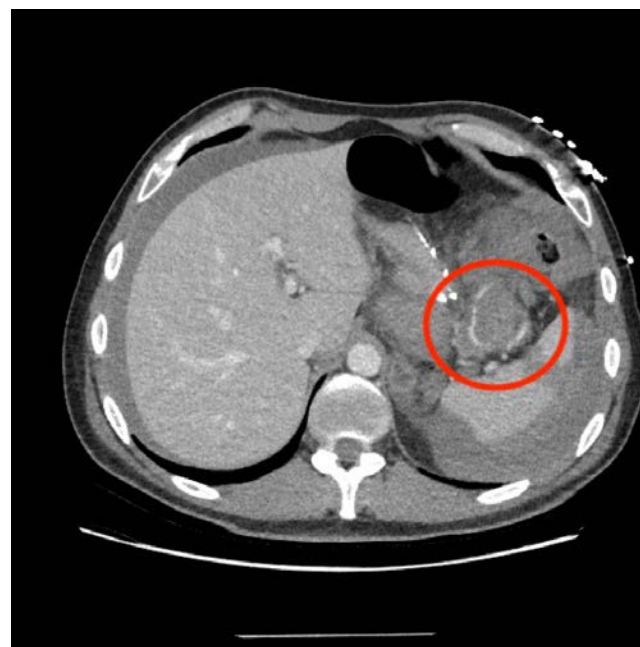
Computed Tomography (CT) image venous phase: view of the globular formation of the pseudo-aneurysm, with iodine contrast effusion (Xenetix 350, 115 mL).
